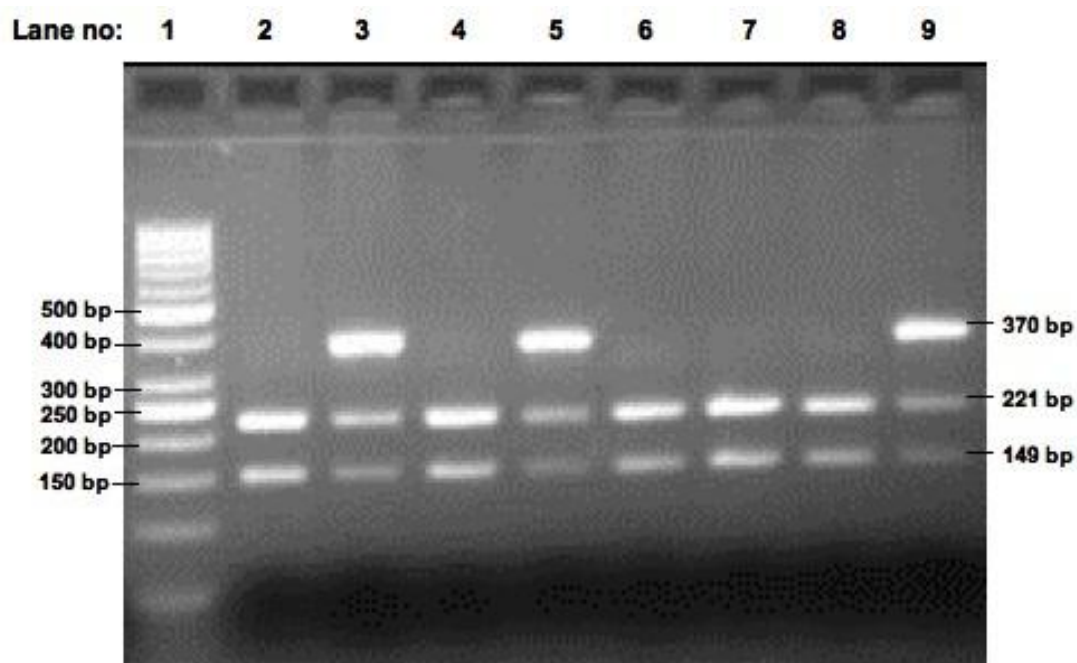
6 3% Agarose gel electrophoresis of *Bsa* I digestion products for rs1999501 SNP region of GABA_{B2}. First lane was loaded with DNA ladder (50-1000 bp), following lanes were loaded with digestion products of the subjects. Lane 2, 4, 6, 7 and 8 show wild type genotype (CC) with 221-bp and 149-bp. Lane 3, 5 and 9 show heterozygous genotype (CT) with 370-bp, 221-bp and 149-bp.
